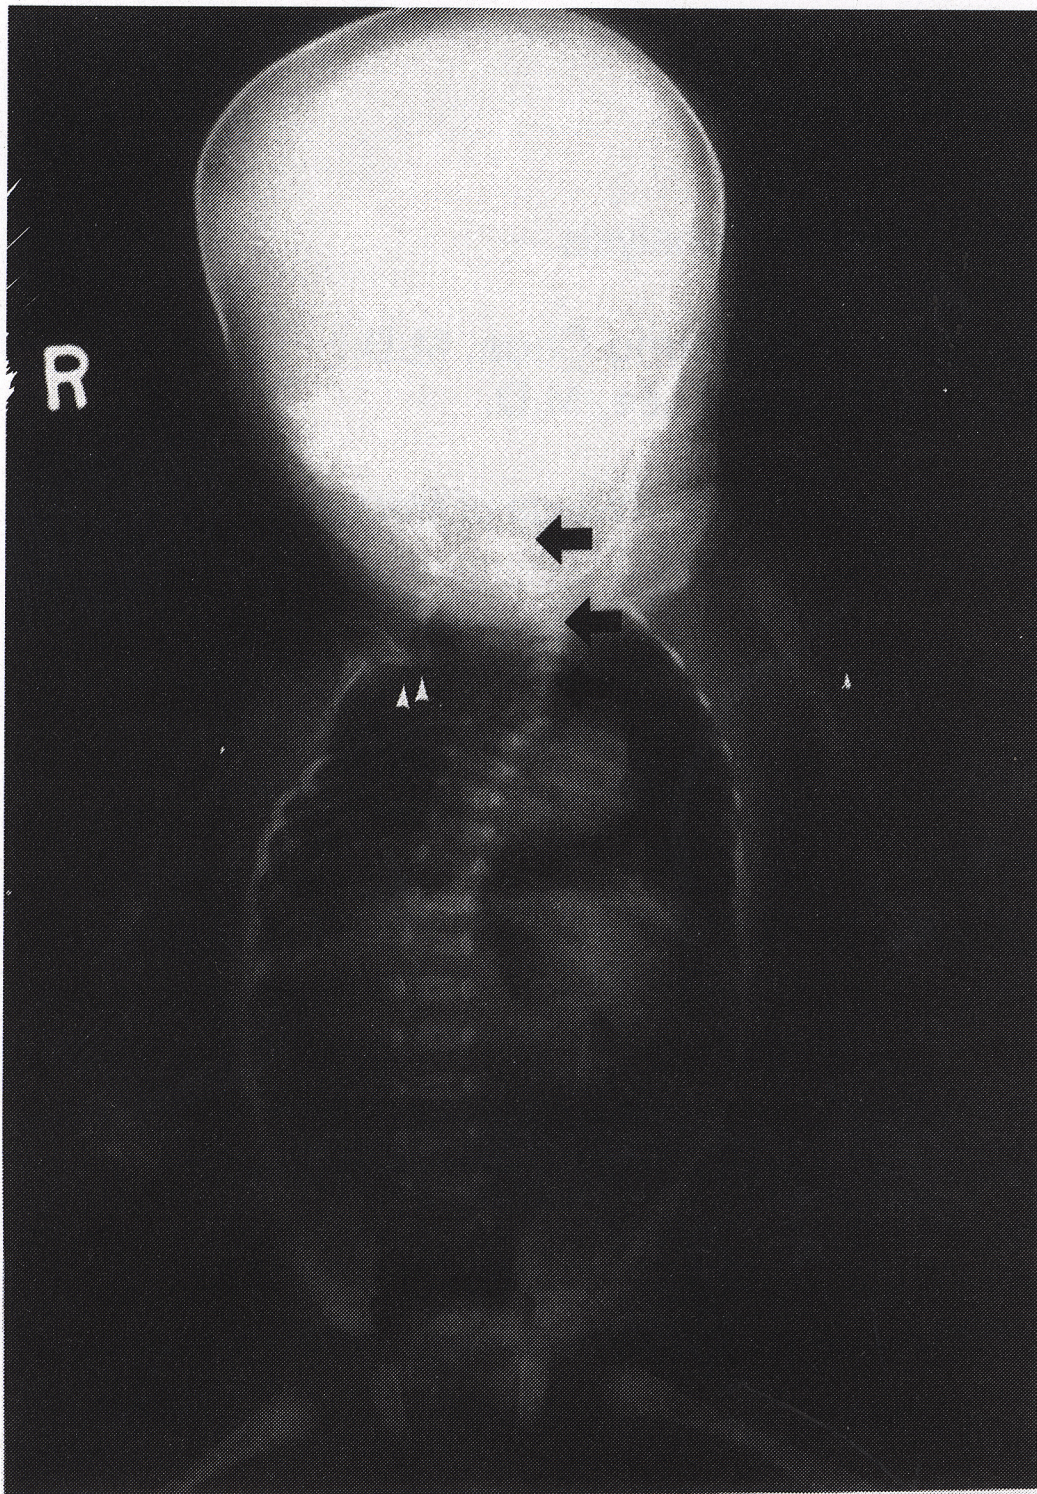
Radiograph shows cervico-thoacic hemivertebrae (arrow) with spina bifida and absence of right upper five ribs (arrow head). There is a right-convex scoliosis.
